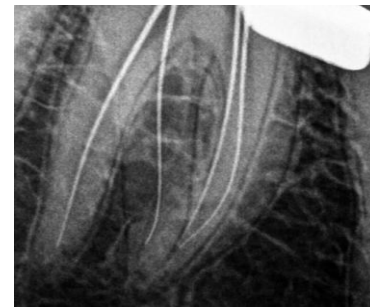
Working length radiograph (extra distolingual root)
